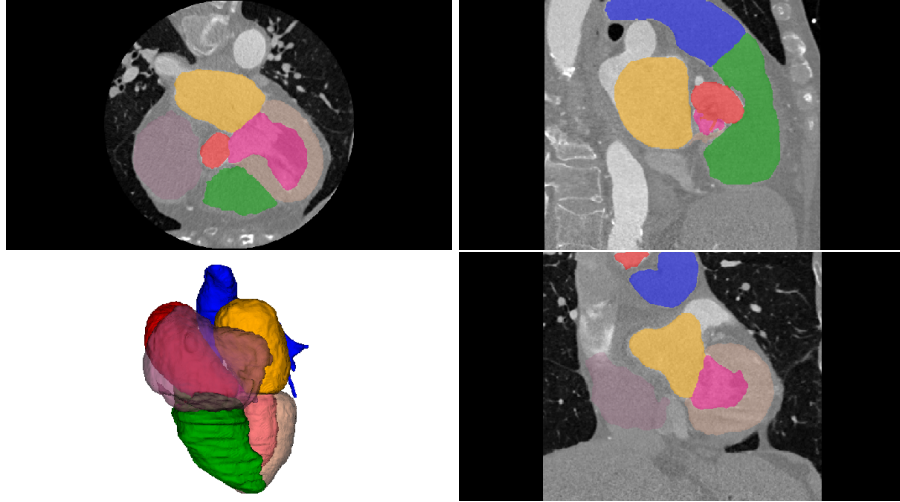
Representative chest CT image of the MMWHS challenge with 3D view of risk structures.
